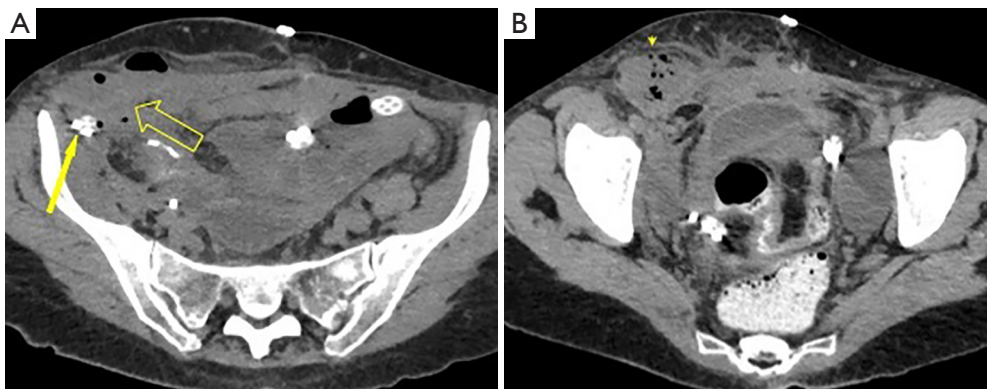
CT-scan imaging revealing the right abdominal-inguinal abscess and cellulitis in case #2. (A) Right iliac fossa abscess (empty arrow), adjacent to the drainage tube (filled arrow) with involvement of the abdominal wall. (B) Protrusion of the abscess in the inguinal canal (arrow head).
